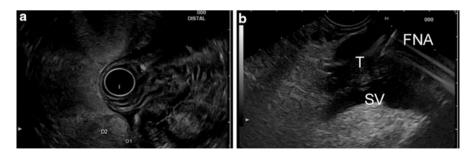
(a) Endoscopic ultrasound of an insulinoma located at the tail of the pancreas. The tumor is isoechoic and measures $D1:9 \times D2:7$ mm. (b) Fine needle aspiration (FNA) under endoscopic ultrasound guidance of a nonfunctioning pancreatic neuroendocrine tumor (T). The tumor is anechoic and in close proximity to the splenic vein (SV)
